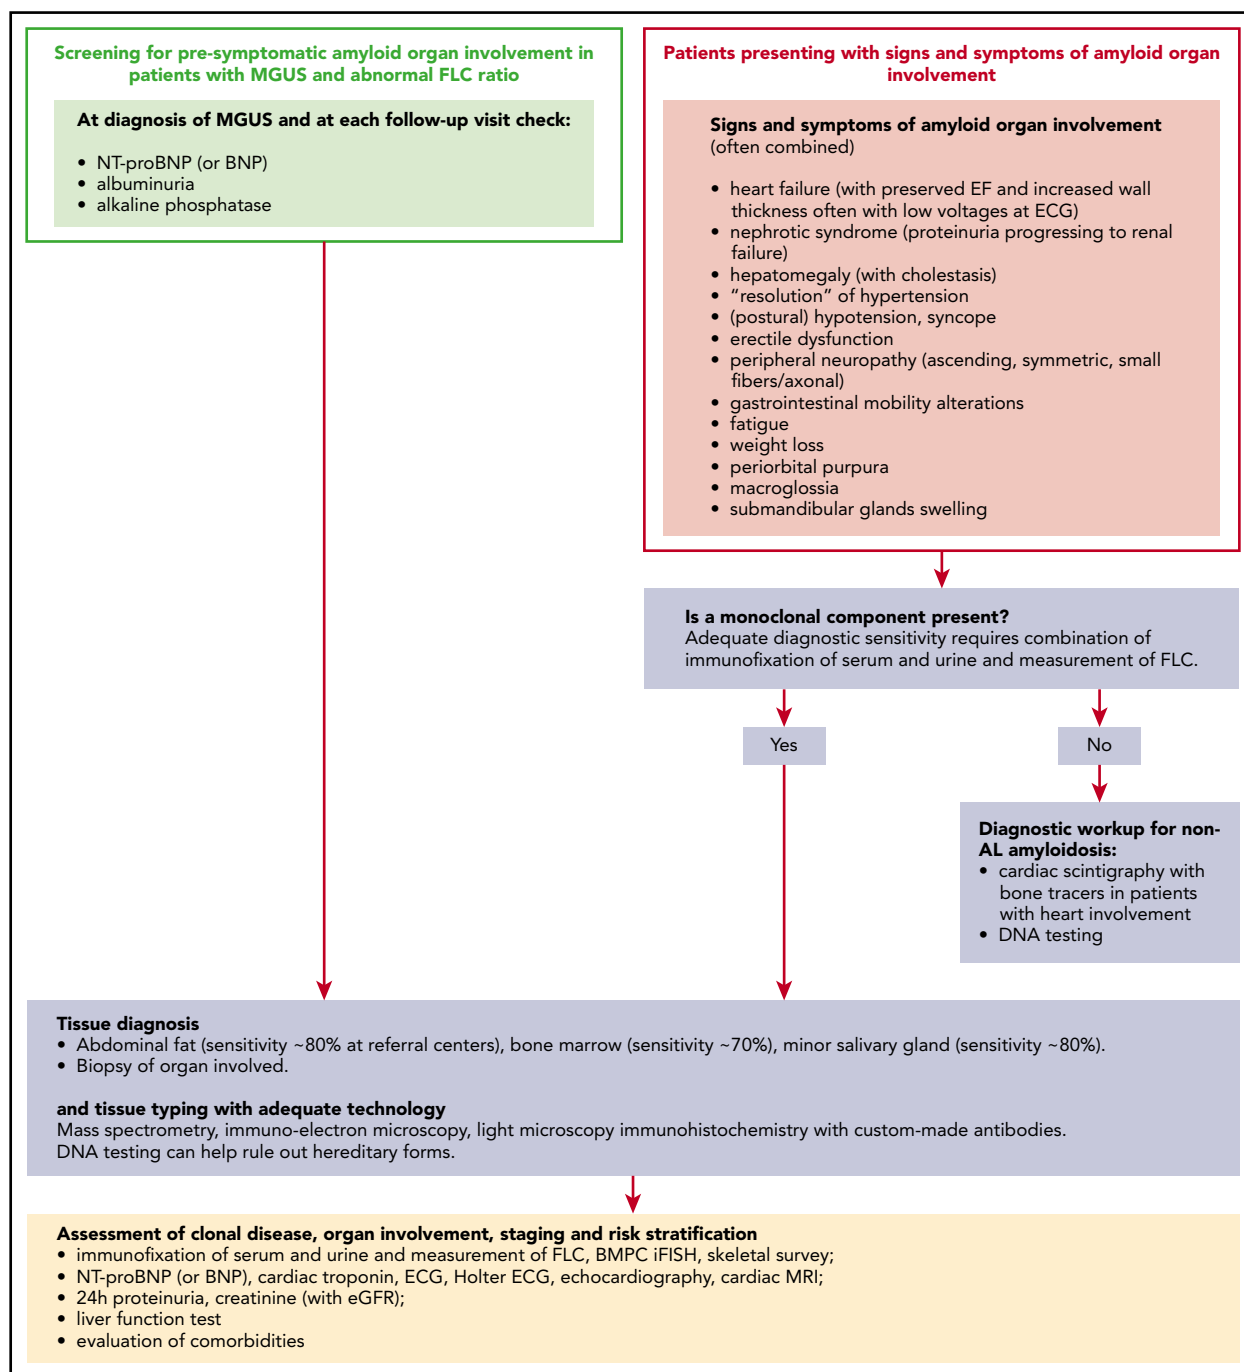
Presenting features and diagnostic algorithm for AL amyloidosis. Amyloidosis can be suspected if elevated biomarkers of organ involvement are detected during follow-up of patients with MGUS or if suggestive symptoms arise. The first scenario is ideal and enables early presymptomatic diagnosis. Based on relative rates of progression, appropriate screening programs should detect 1 patient with MGUS progressing to AL amyloidosis for every 7 to 10 who develop multiple myeloma. In patients with MGUS in whom elevated NT-proBNP or BNP is found, cardiac magnetic resonance imaging can be used as a higher specificity confirmatory test. If symptoms of systemic amyloidosis arise in a patient in whom a preexisting monoclonal gammopathy is not known, the first step should be searching for a monoclonal component, particularly if heart involvement is suspected, so as not to delay diagnosis. Only the combination of immunofixation of both serum and urine and FLC measurement grant adequate diagnostic sensitivity to detect amyloidogenic monoclonal proteins. MS-based methods are under investigation. Patients with suspect cardiac amyloidosis without monoclonal components can have an attempted nonbiopsy diagnosis of ATTR amyloidosis with cardiac scintigraphy with bone tracers. Validated tracers are ^{99m}Tc -diphosphono-propanodicarboxylic acid, ^{99m}Tc -pyrophosphate, and ^{99m}Tc -hydroxymethylene diphosphonate. DNA analysis is necessary to differentiate between hereditary and wild-type ATTR amyloidosis and to rule out other rarer hereditary forms. All other patients require a tissue diagnosis. Amyloid deposits can be found in abdominal fat, minor salivary
